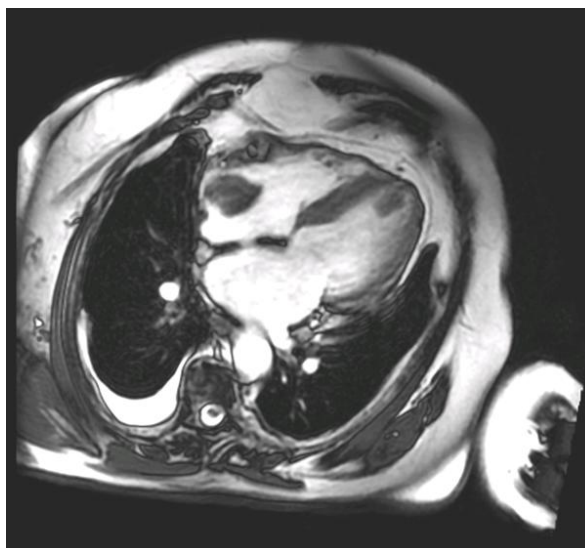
MRI FIESTA 4 chambers view (performed in 2017) showing a bilateral right atrial (34 x 20 mm) and left ventricular (18 x 13 mm) thrombus. Moderate right pleural effusion associated.
